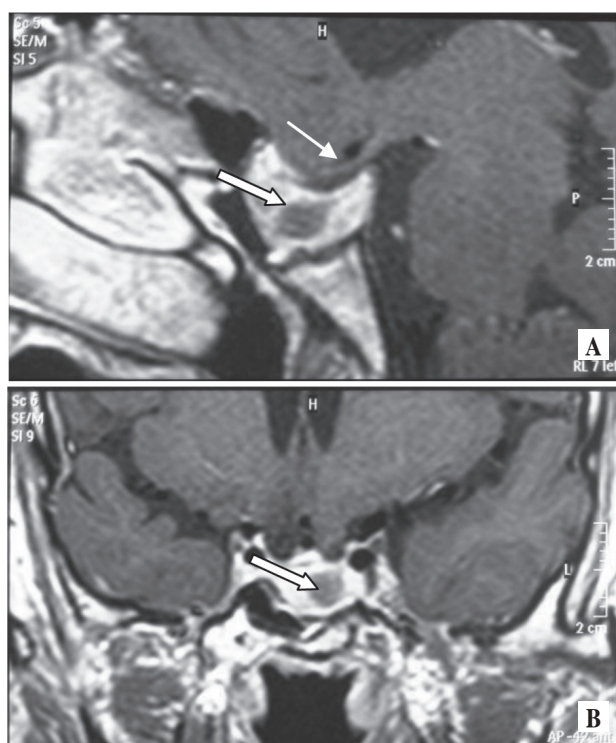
Pituitary T1-weighted sagittal (A) and coronal (B) MRI scan respectively, after surgical resection of adenoma showing a residual tumour mass (8mm) in the sella (arrows). The reconstruction of the sella cavity is depicted. The left optic nerve is shown normal (thin arrow).
